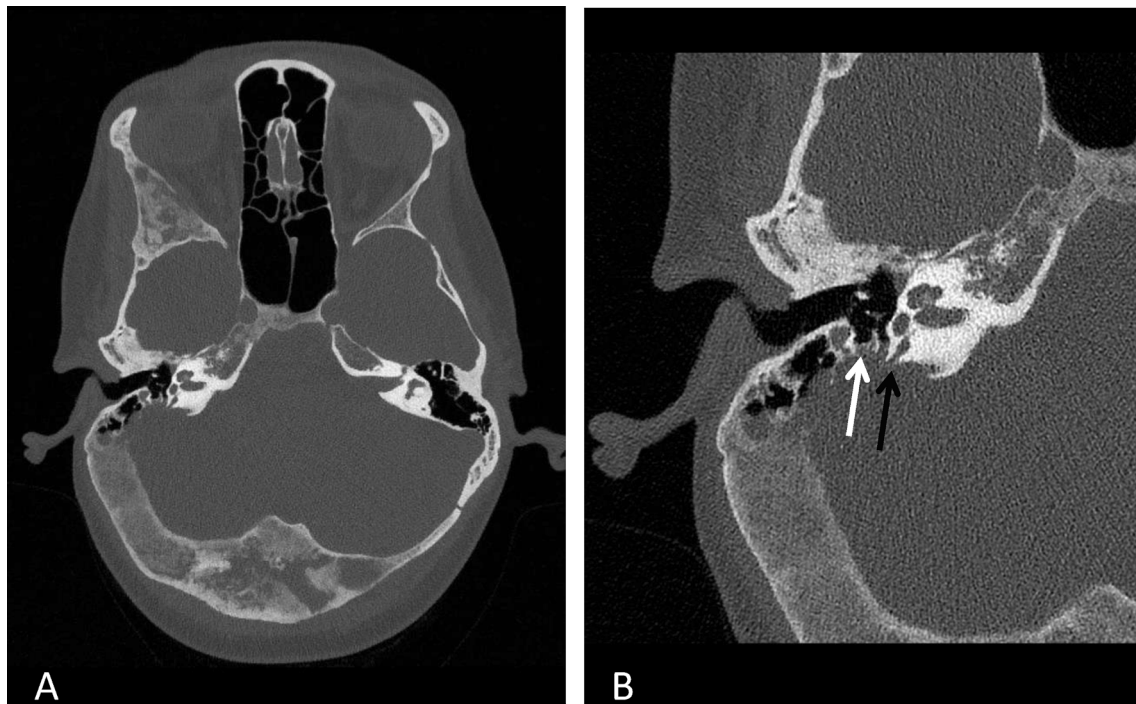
A) Transversal CT image. A mostly right-sided thickening of the skull is seen with ground glass aspect of the sphenoid wing, petrosal apex and occipital bone. Some cystic areas can be identified. A classic aspect of fibrous dysplasia. B) Detailed image of the right petrosal bone. Posterior osseous erosions are seen, directly adjacent to the ground glass appearance of the occipital bone. The white arrow shows erosion of the facial canal and the black arrow erosion of the posterior semicircular canal.
